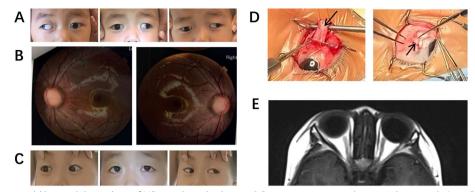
Case 3: A 3-year-old boy with hypoplasia of MR muscles in both eyes. A Preoperative picture showing a large-angle (> 90 PD) of left exotropia in the primary position. Three gaze pictures revealed deficits of adduction beyond the midline (-3 limitation on a scale of 0 to -4) during elevation in both eyes. B Fundus photography revealed large cups in both eyes. C Muscle fibers of the left MR muscle (left arrow) were thin. Surgeon's view showing degeneration of the MR muscle (right arrow), which resembled connective tissue, in the right eye. D Postoperative MRI scans did not show any obvious abnormalities of the orbits or EOMs. E Good correction of exotropia was confirmed at the 2-year follow-up
